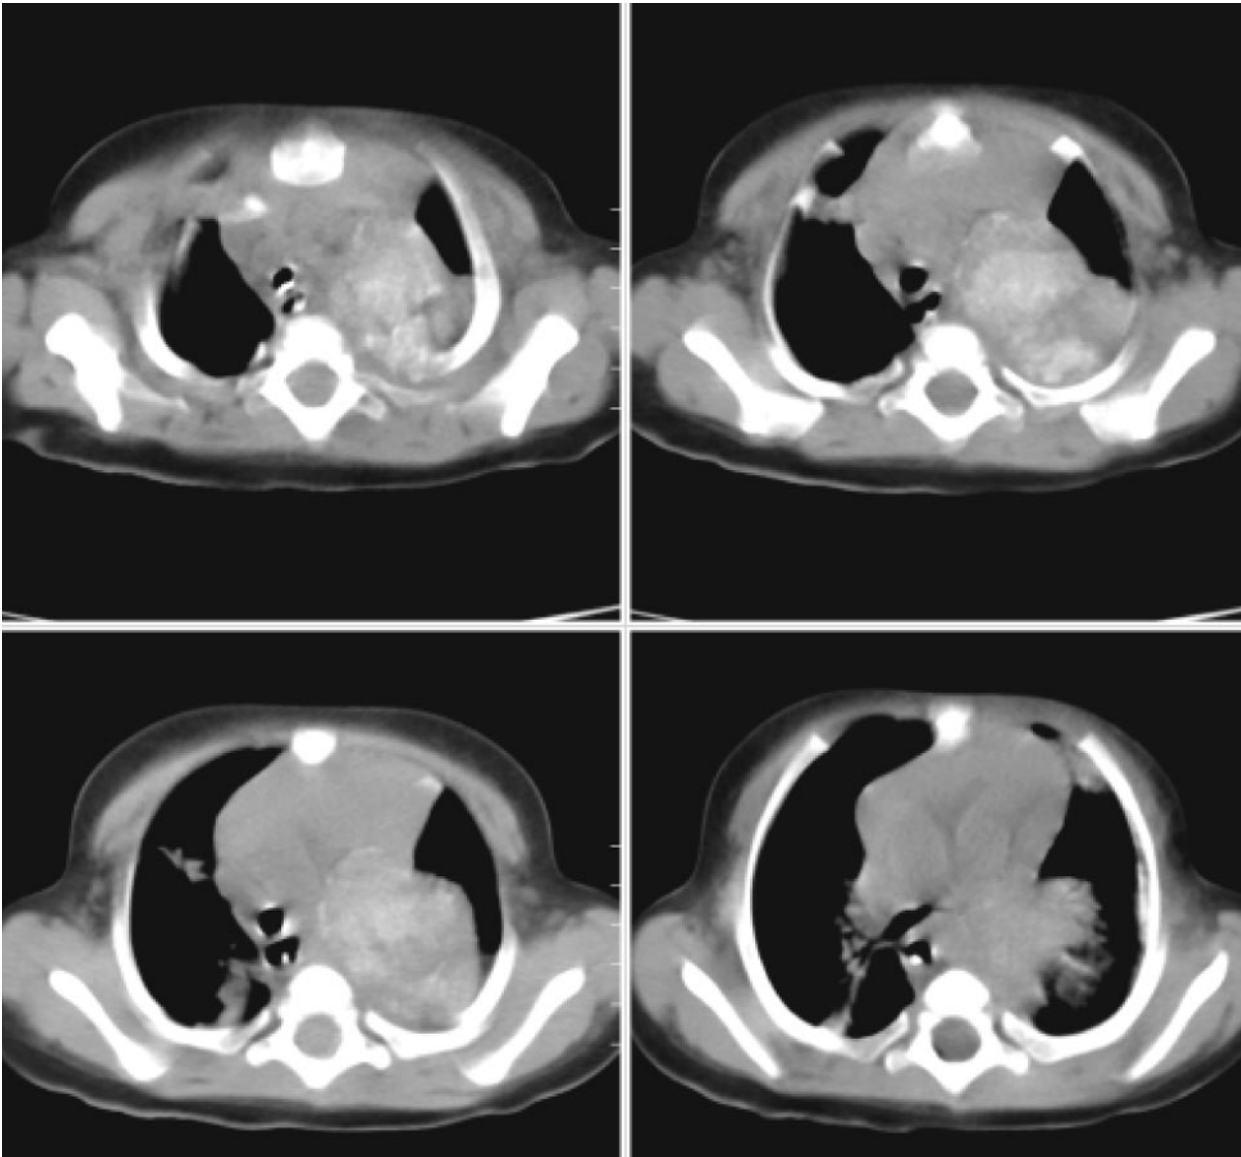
Computed tomography scan of the thorax shows a large neuroblastoma at the apex of the left thorax.
